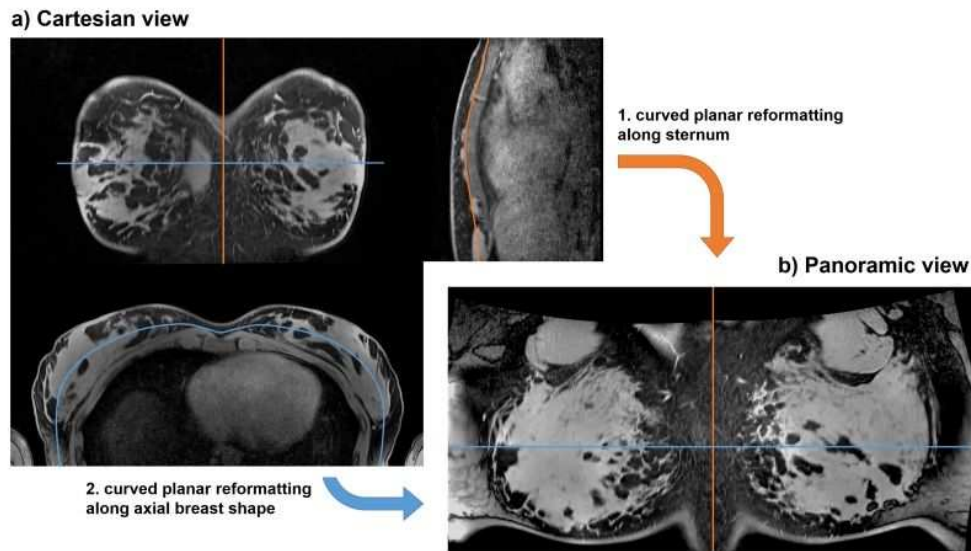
Panoramic breast MRI using two consecutive CPRs with manually placed reformation curves in blue and orange (from [43]).
